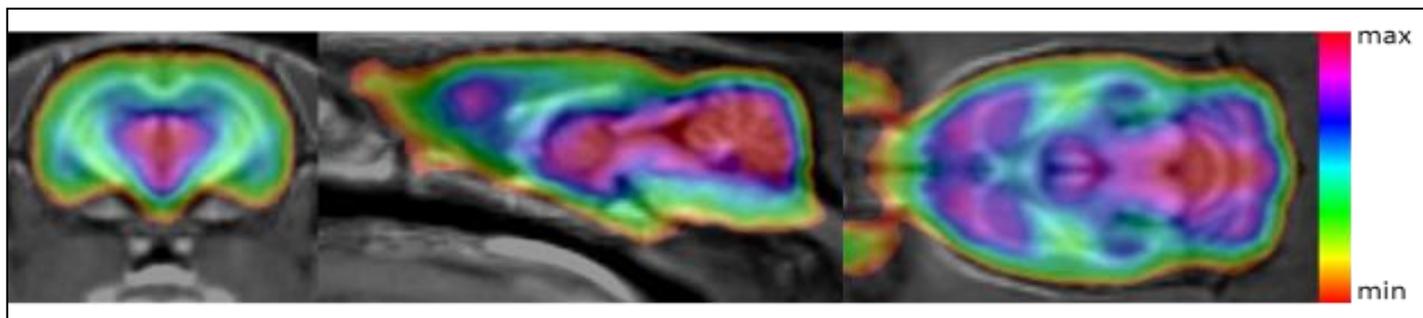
Fused PET-MRI-Template in coronal, sagittal und transversal view.
